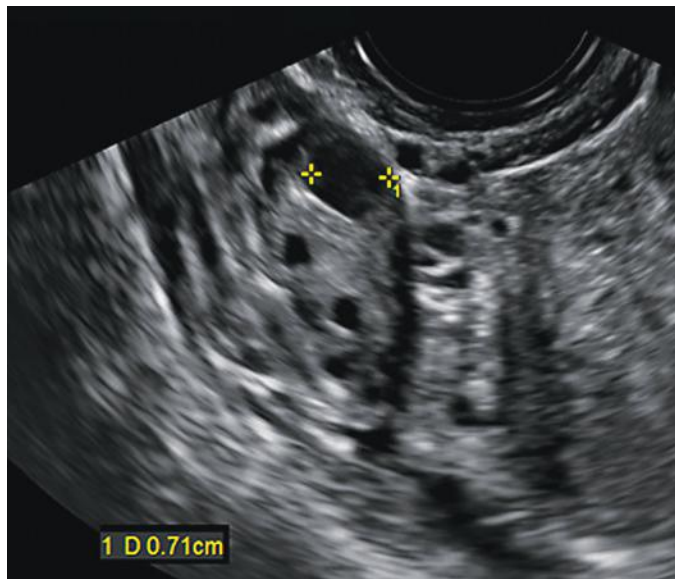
Normal ultrasound appearance of the ovary. Coronal gray-scale image of the right ovary on a baseline examination in an infertility patient. There are several antral follicles noted, the largest measuring 7 mm (*calipers*).
